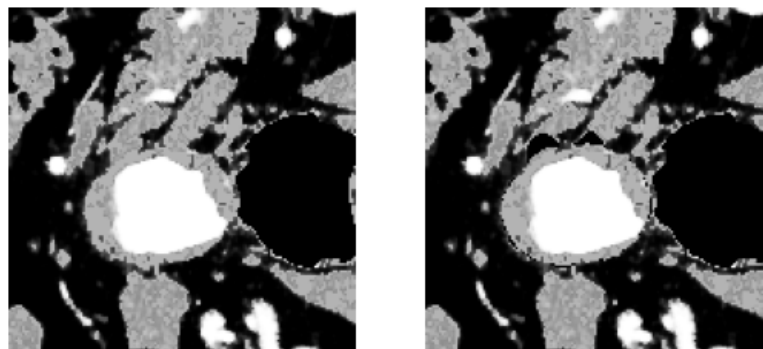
CTA before and after the removal of the spurious extensions. (Patient 2)
